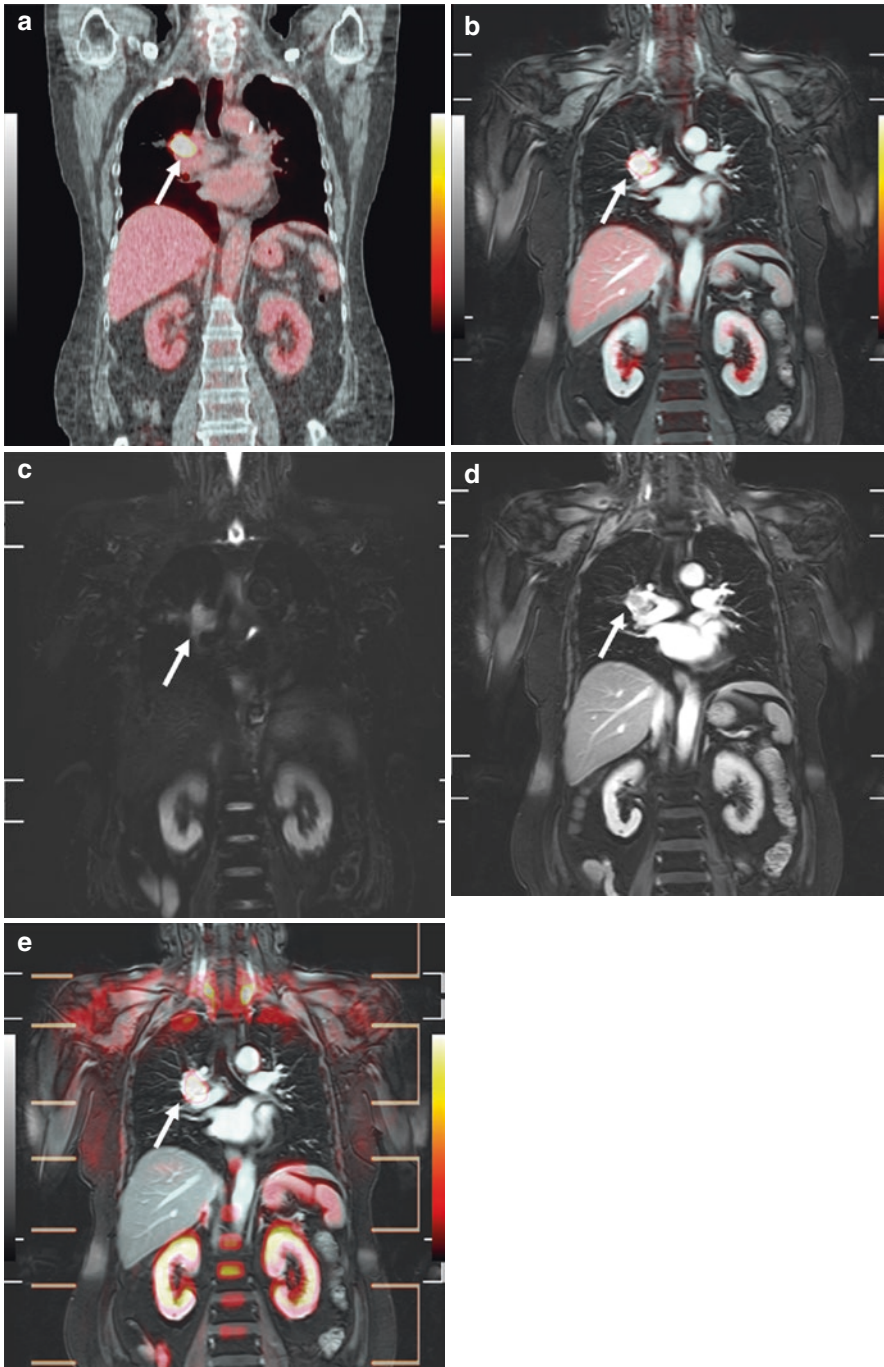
A 65-year-old female patient with right hilar lymph node metastasis due to squamous cell carcinoma. (a) PET/CT shows enlarged right hilar lymph node metastasis (*arrow*) with high FDG uptake. (b) PET/MRI, a combination of PET and contrast-enhanced (CE) fast and segmented 3D T1-weighted spoiled GRE (i.e. Quick 3D) sequence data, shows enlarged right hilar lymph node metastasis (*arrow*) with high FDG uptake. (c) Whole-body STIR FASE image shows enlarged
